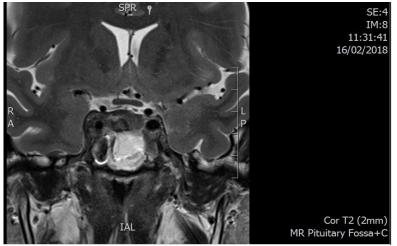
Progress MRI pituitary post-IPSS
